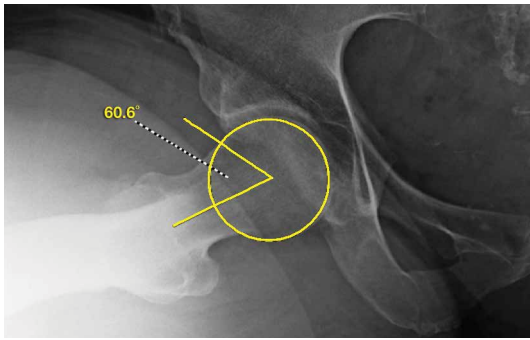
α angle. Dunn (90°) lateral radiograph of a 38-year-old woman allows evaluation of femoral head sphericity and measurement of α angle. Angle (61° here) is formed by long axis of femoral neck and point where femoral head–neck junction extends beyond circle of best-fit. Normal α angle is $>42^\circ$.
